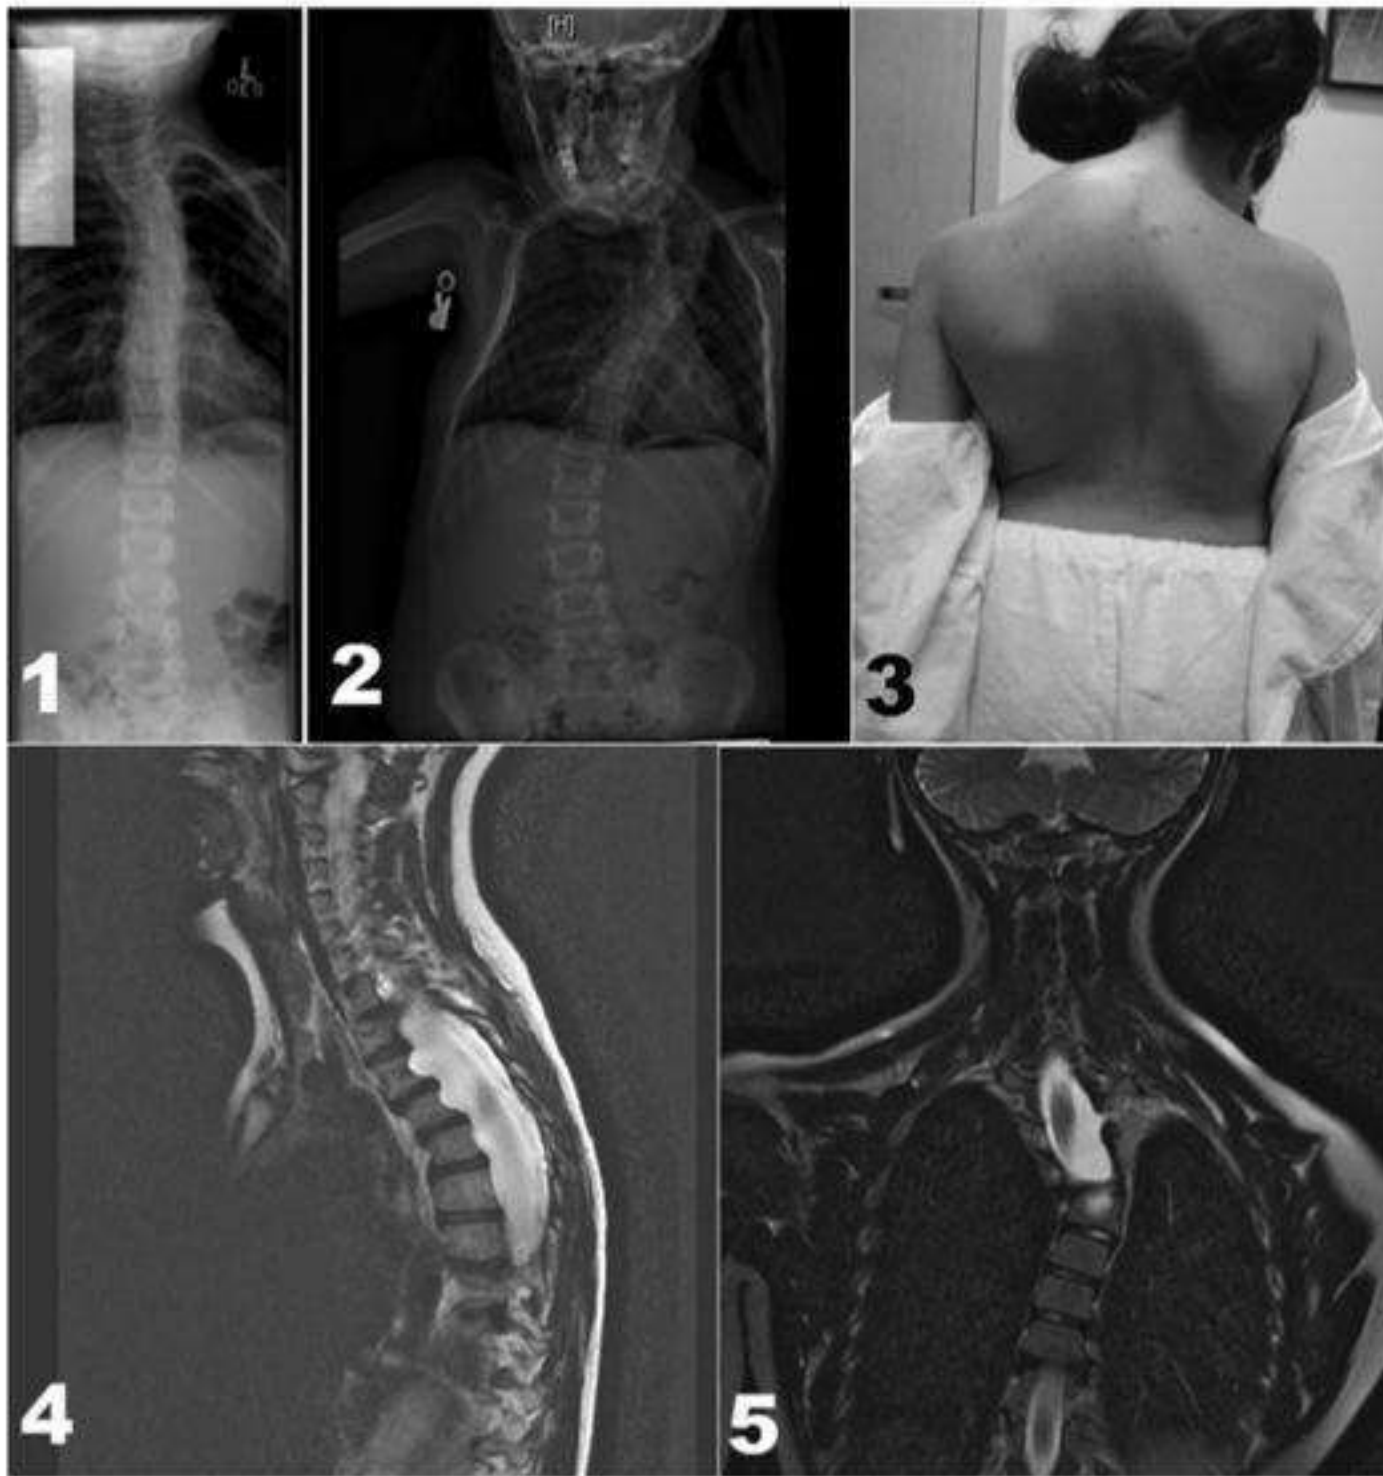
Dystrophic scoliosis in a child with neurofibromatosis scoliosis. 1, 2: There was a rapid progression in the severity over 2 years. 3: Café au lait spots and a sharply angled kyphoscoliosis. The kyphosis is more pronounced than the scoliosis. 4, 5: MRI scan shows large dural ectasia and scalloping of the posterior vertebrae. 5: There is a large plexiform neurofibroma in continuity with a nerve root.
